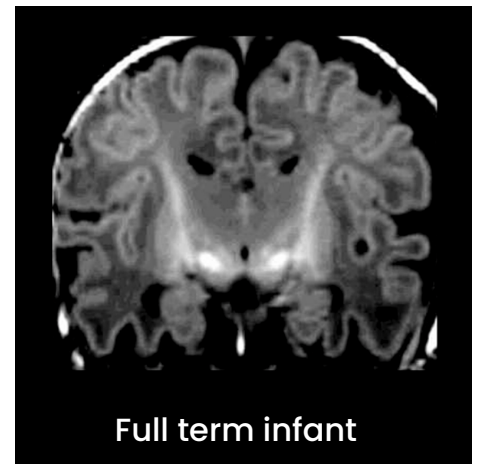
A coronal view with structural MRI of a full term infant
